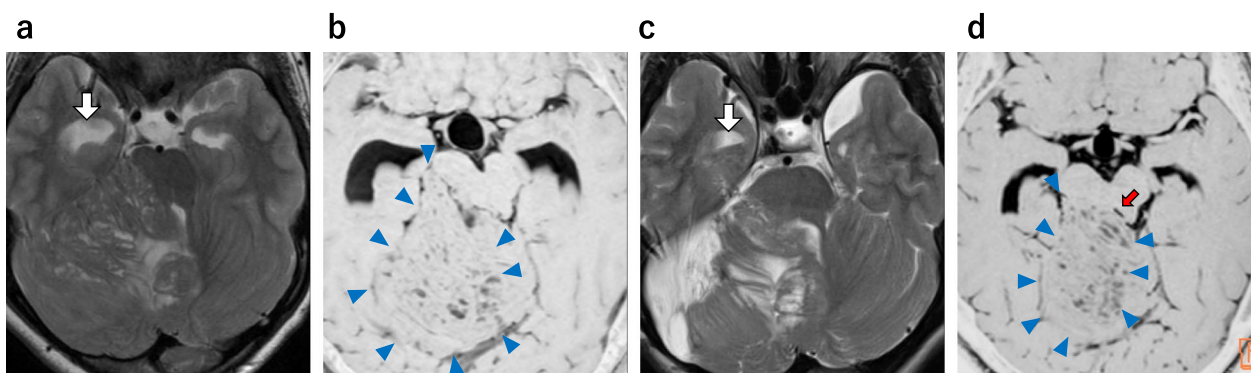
Magnetic resonance images before craniotomy (a, b) and 11 months after surgery (c, d). a T2-weighted image. A cerebellar tumor was observed centered in the right cerebellum, compressing the brainstem posteriorly. The inferior horn of the lateral ventricle is enlarged (white arrow). b Constructive interference in the steady state image. The location of the tumor was clearly visible (blue arrowheads). c The tumor was partially removed, and compression to the brainstem improved. The inferior horn of the lateral ventricle also shrank (white arrow), and the hydrocephalus improved. d Constructive interference in the steady state image. Compression of the brainstem by tumor (blue arrowheads) decreased, and stenosis of the midbrain aqueduct improved (red arrow)
